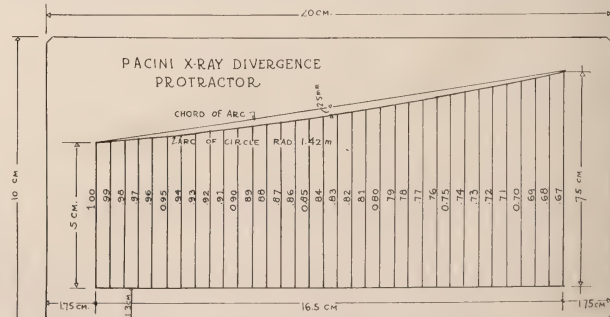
Divergence protractor. Made of transparent celluloid. It is applied over the film or plate to measure the roentgenographic length of the bob. The coefficient corresponding to the roentgenographic length is applied to all median sagittal measures, thus correcting the roentgenographic measures to true values.
